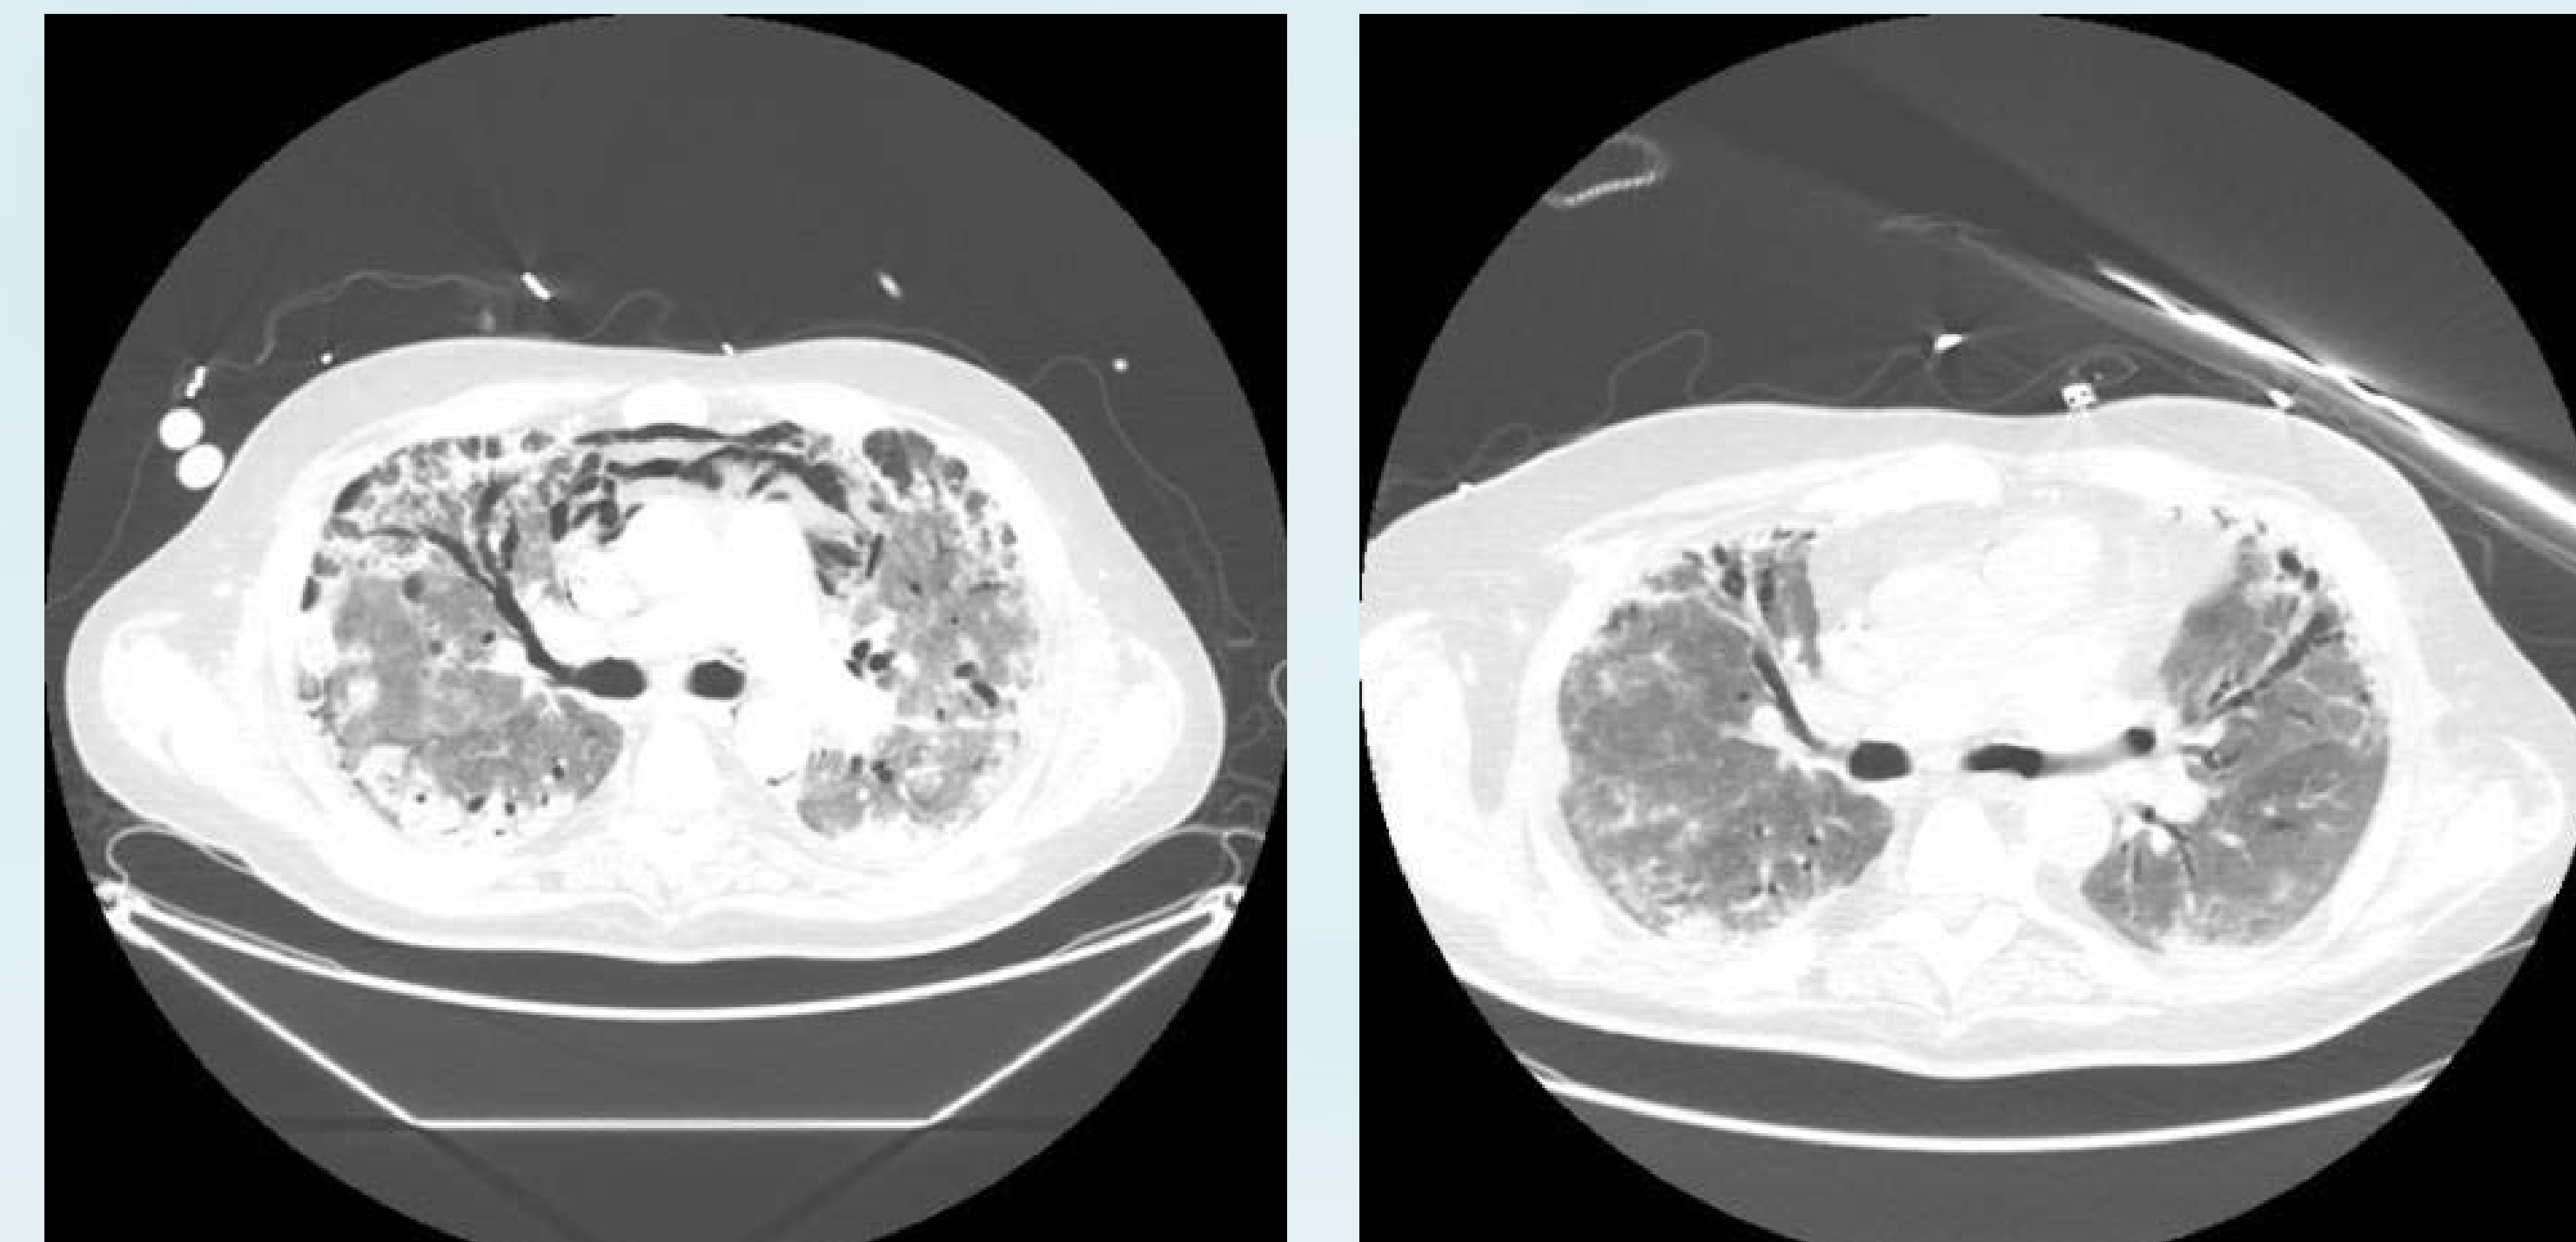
Figure 2: (Patient B) 26 year old female with Influenza A H1N1 initial chest CT scan on left side. The follow up chest CT scan 314 days post ECMO is on the right side.
